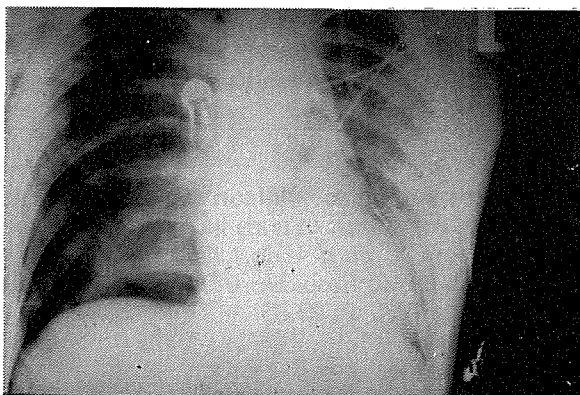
Chest X-Ray of 26 year old man with (R) pneumothorax, (L) haemothorax, pneumomediastinum and surgical emphysema with pectoral muscle fibers showing in contrast.
